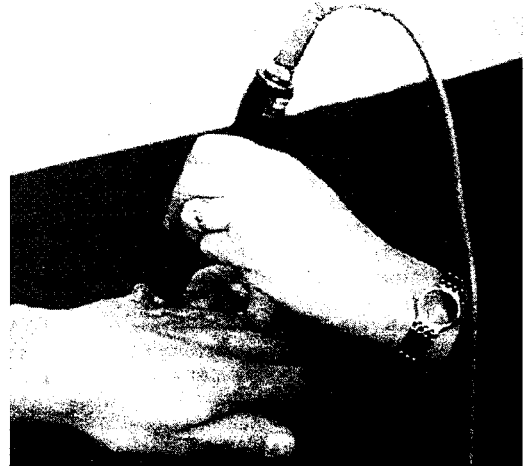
Ultrasound applied to the dorsum of the hand over the metacarpophalangeal joints of digits 4 and 5*
